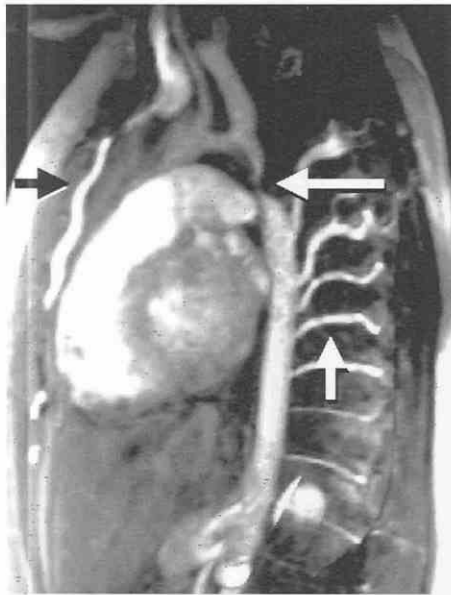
Sagittal oblique gadolinium-enhanced MR image demonstrates severe postductal coarctation (long arrow) with prominent intercostal aorta (short arrow). Note the prominent internal mammary artery (black arrow).
